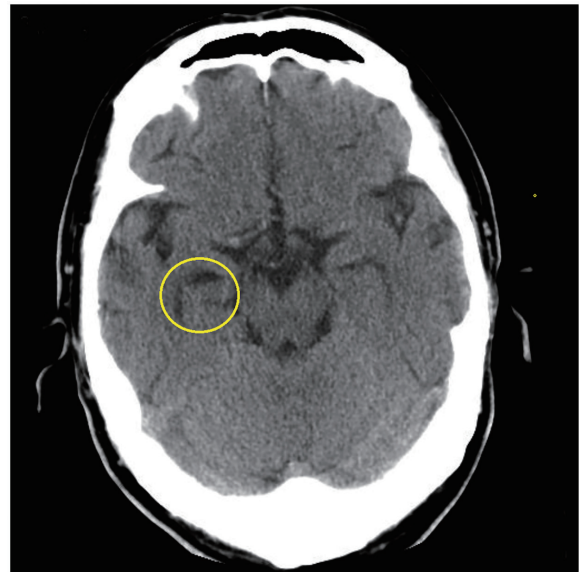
Brain computed tomography findings at the first visit. Dilatation of the lower horn of the right lateral ventricle was suspected.
